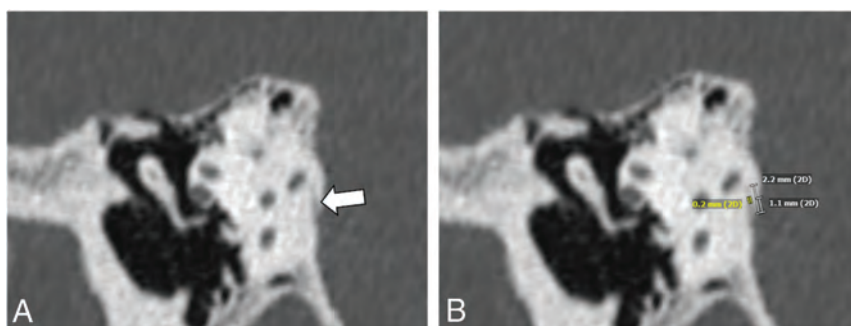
FIGURE Representative Pöschl reformatted multidetector CT image of a 59-year-old patient shows a small VA (A, white arrow) with measurement (0.2 mm) at the midpoint (B).
